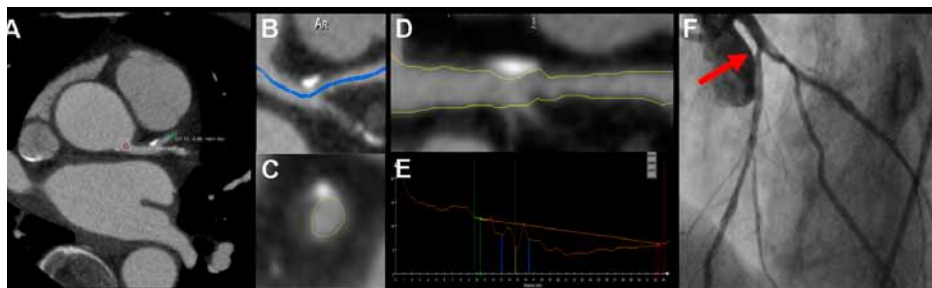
Quantification of stenosis severity on multidetector row computed tomography (MDCT). Diameter coronary stenosis can be manually determined by assessing the lumen diameter at the lesion site and proximal/distal reference sites using either axial slices (panel A) or cross-sectional images perpendicular to the centerline of the vessel (panel B). Similarly, area stenosis can be calculated by tracing lumen areas on the cross-sectional images (panel C).
